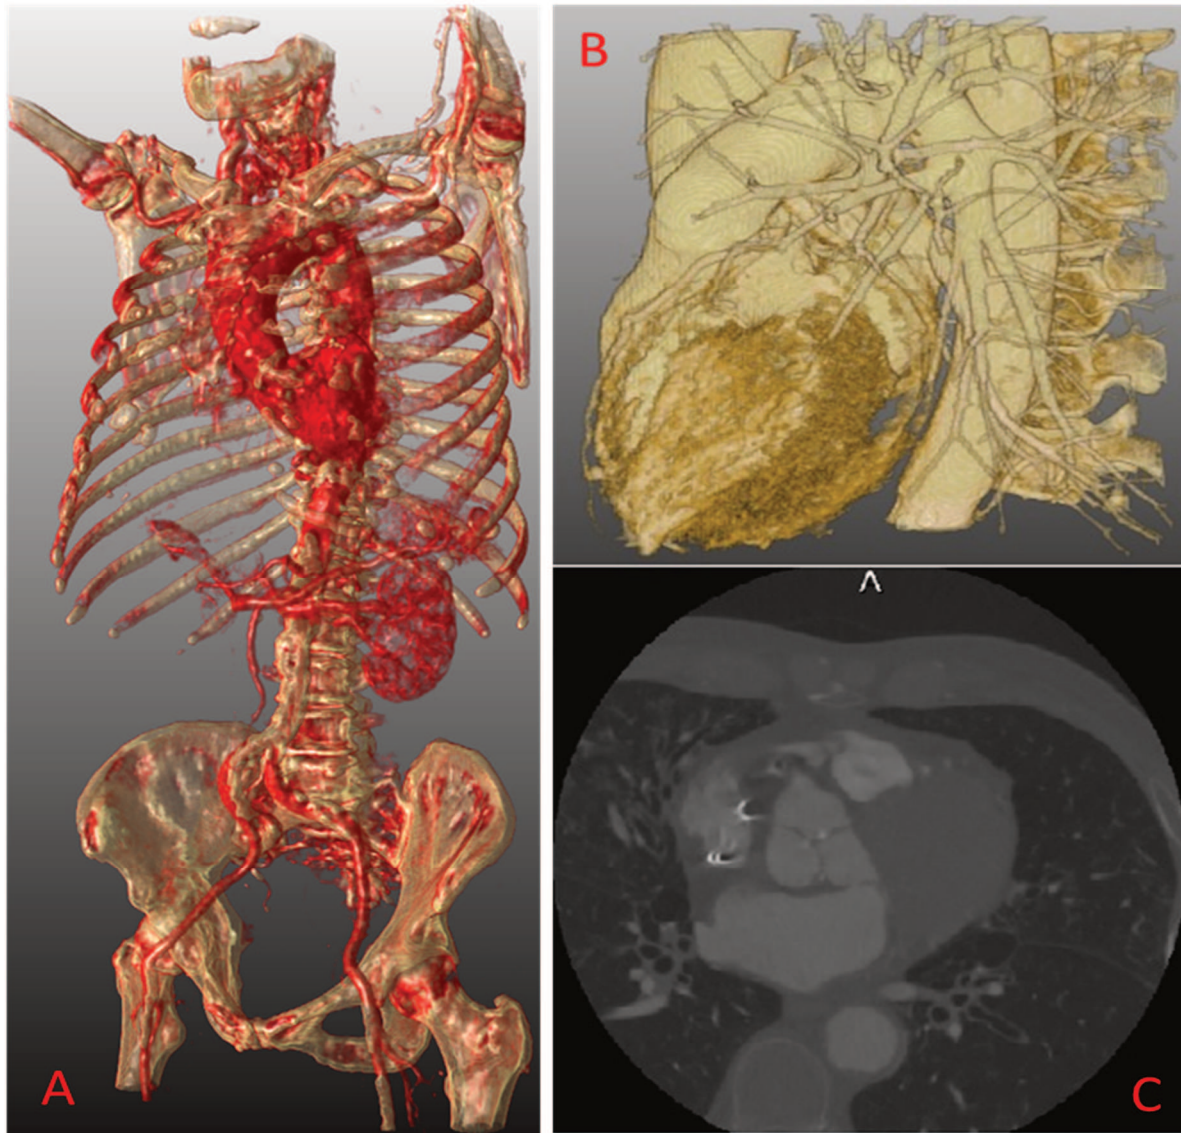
CT images for pre-operative TAVR planning: A. CTA image for vascular access, B & C. cardiac CTA image for aortic root: B. 3D view C. 2D view
